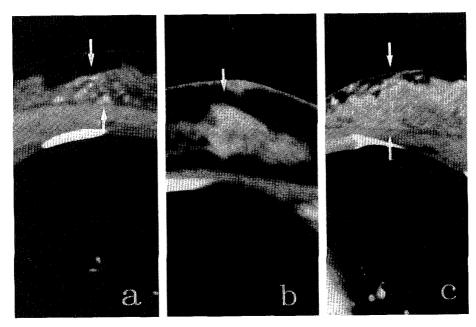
(a) An example of strong nodular enhancement in breast tissue detected by CE-CT. (b) Moderate enhancement. (c) Weak enhancement.
